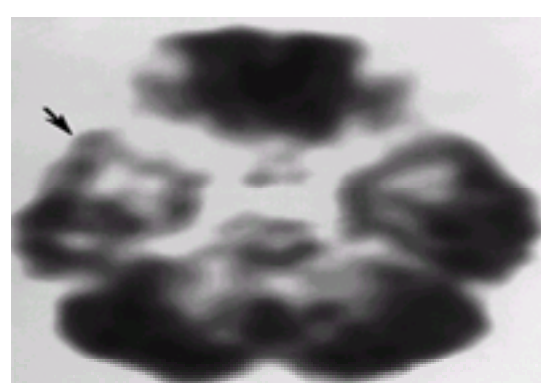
Patient with long-standing partial-complex seizures; note reduced FDG uptake in the right temporal lobe (arrow) compared to the left.
